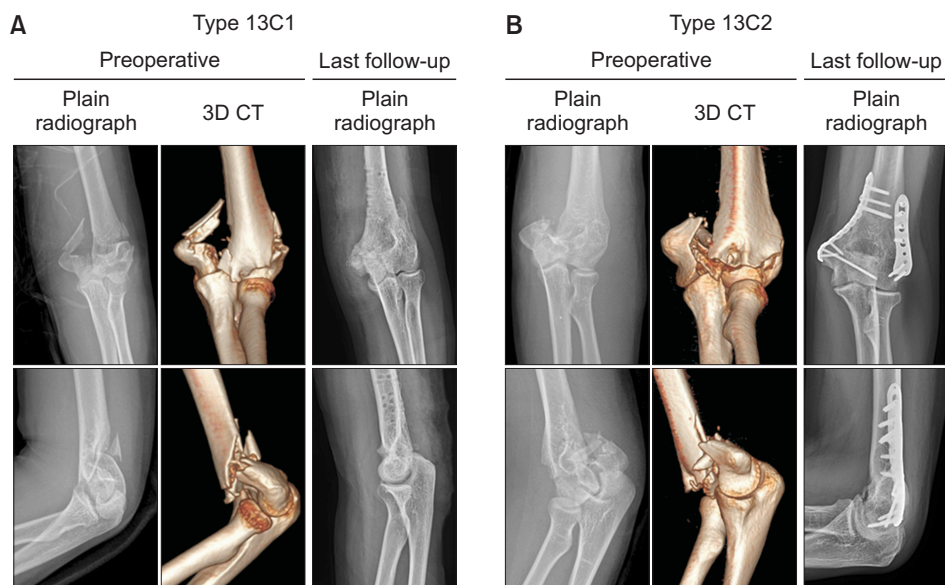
Preoperative and postoperative plain radiographs and three-dimensional reconstructed computed tomography images of each type of distal humeral fracture. (A) Type 13C1 fracture of a 49-year-old woman with a slip and fall injury. (B) Type 13C2 fracture of a 28-year-old man who was injured while playing soccer. 3D: three-dimensional, CT: computed tomography.
